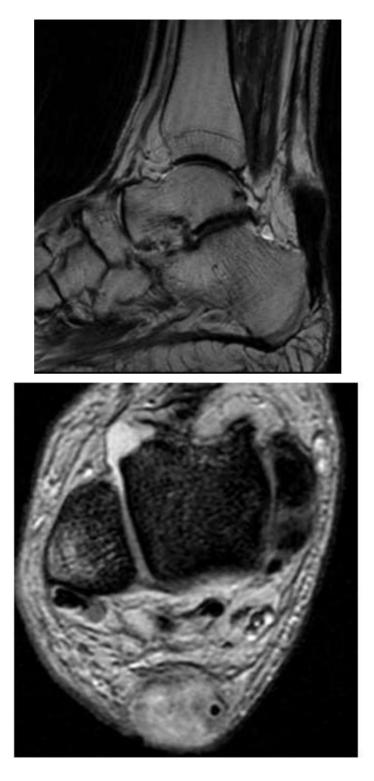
(a) and (b) shows MRI Sagittal T2W and axial T2W images of foot with complete rupture of Achilles tendon
